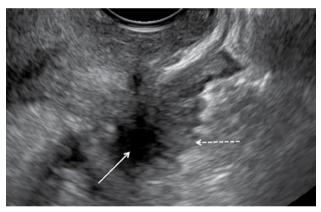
Ultrasound, sagittal plane. Hypoechoic nodule in the rectovaginal septum.
